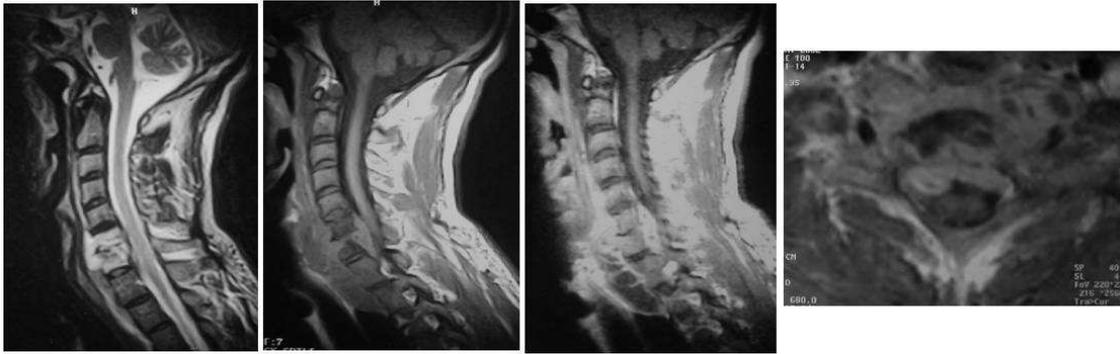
Typical tuberculous spondylitis in 37 years-old woman. Sagittal T2,T1-weighted (pre and post contrast) and axial T1 post contrast images of cervical spines show heterogeneously T2 hyperintense signal and T1 enhancing signals involving C6-C7 vertebral bodies and intervening disc with epidural mass and anterior prevertebral subligamentous spread from D1 to D3 vertebrae.
